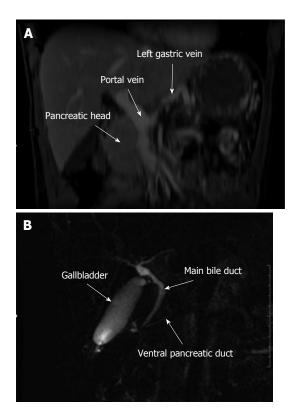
Coronal magnetic resonance imagery showing lack of the body and tail of the pancreas and of the splenic vein (A), magnetic resonance cholangiopancreatography showing the common bile duct joining the ventral pancreatic duct at the posterior part of the head of the pancreas (B). The dorsal pancreatic duct is not visible.
